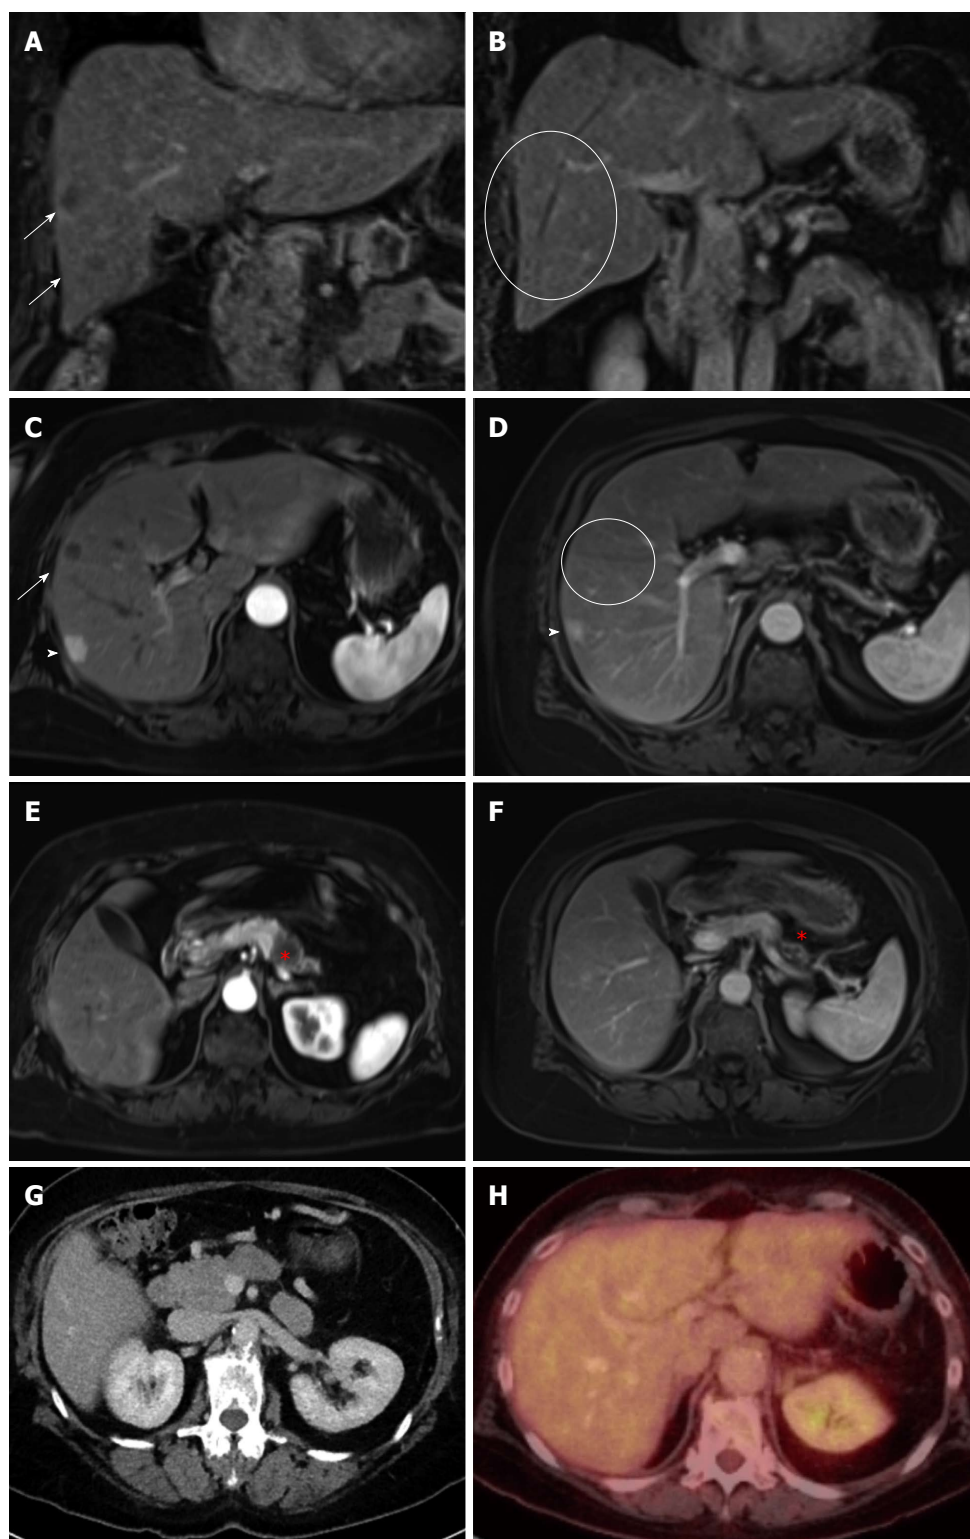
Computed tomography, magnetic resonance imaging and positron emission tomography images of patient 1. Coronal (A, B) and transversal (C-F) T1w contrast-enhanced MRI images demonstrated regredient primary malignancy (star) in the tail of pancreas (E, F) and regredient hepatic metastases (arrow, cycle) in the right liver lobe (A, B, C, D). An additional hemangioma (arrowhead) was observed. Postoperative CT (G) and PET-CT (H) showed complete resection of the primary tumor and no visible metastasis. CT: Computed tomography; MRI: Magnetic resonance imaging; PET: Positron emission tomography.
